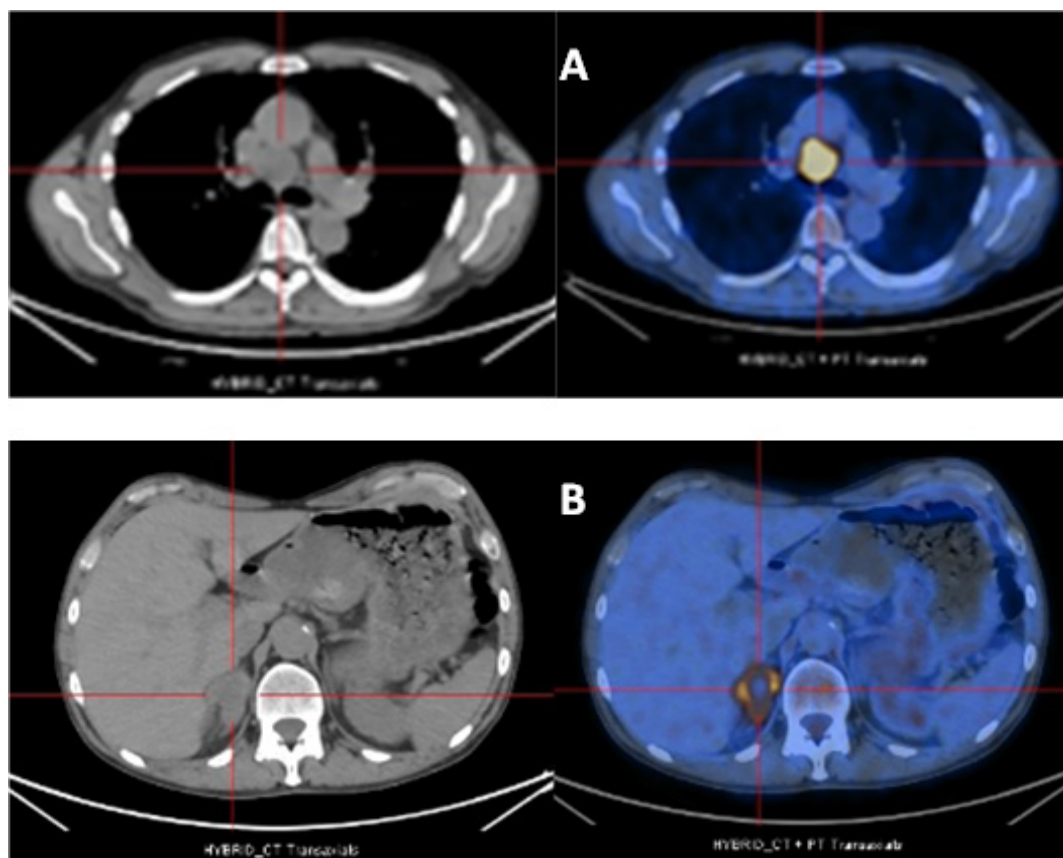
PET/CT images showing increased metabolic activity in the mediastinum (A) and in right adrenal gland; (B) before starting chemotherapy.
